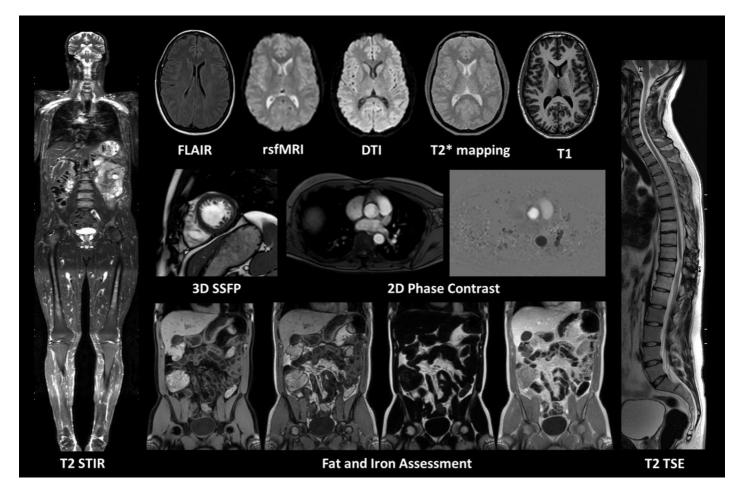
Magnetic resonance imaging acquisition protocol.
